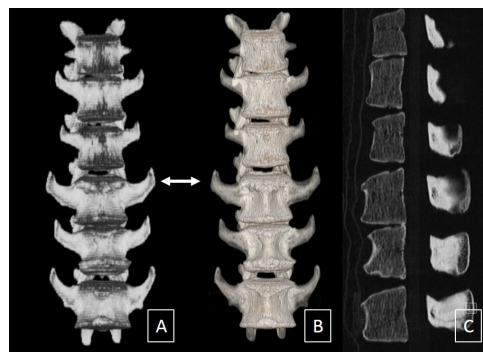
Example of a thoracic vertebra. 3D volume rendered (A) Lateral oblique and (B) Frontal Projections) and Sagittal (C) and Coronal (D) CT reconstructions of the T11 vertebra.
